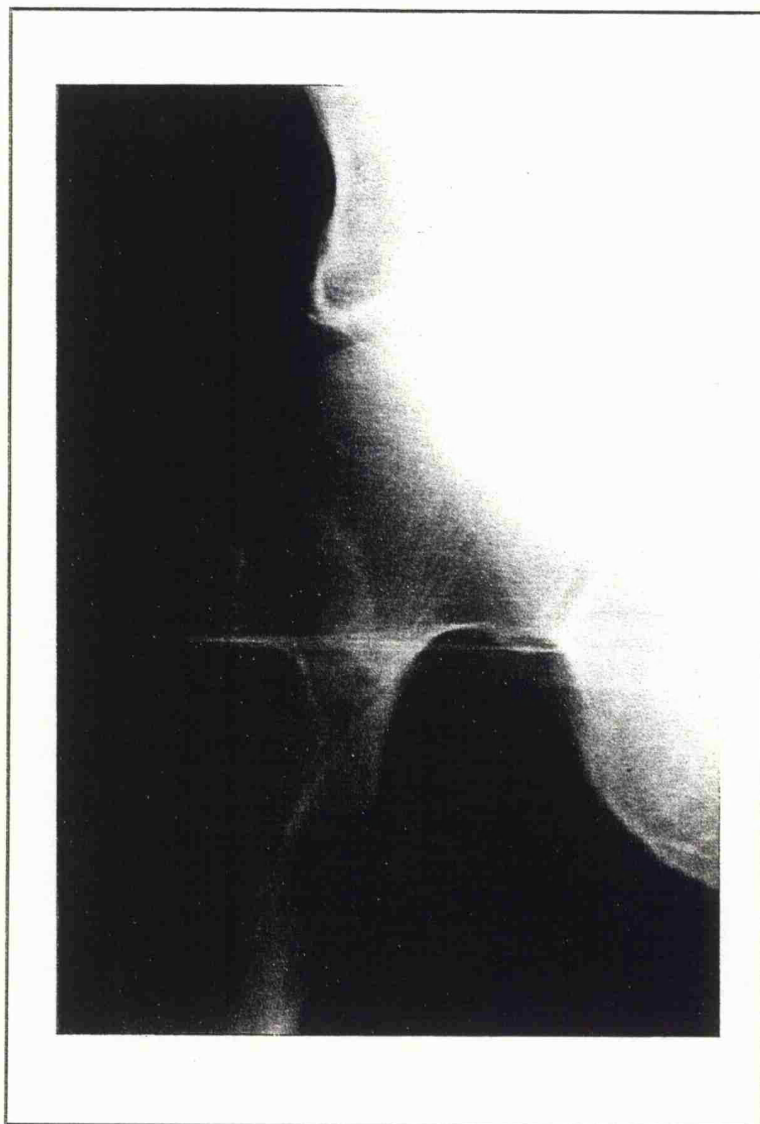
An antero-posterior radiograph of a Garden Stage II fracture showing the trabeculae of the femoral neck and head remaining in line.
